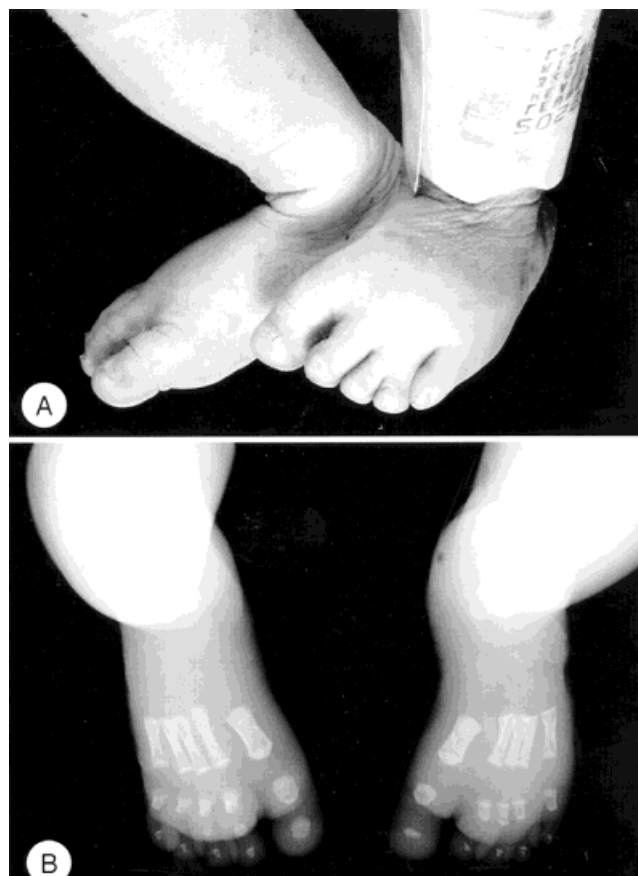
Case 3. Cutaneous syndactyly of the right 3rd-4th toes (A) and radiographs showing absence of the middle phalanges of the right 1st-5th and left 3rd and 4th toes (B).
